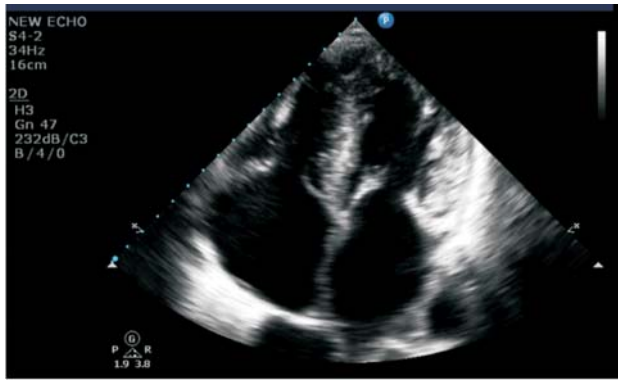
Apical four chamber view showing bi-atrial enlargement and concentric LVH.
